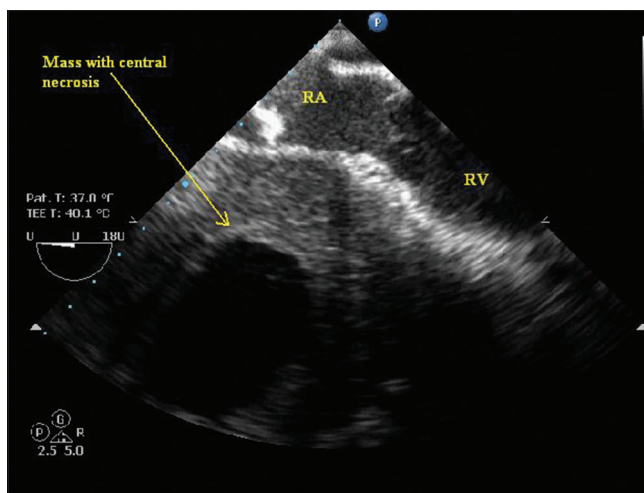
Transesophageal echocardiography image showing mediastinal mass lateral to right atrium and right ventricle
